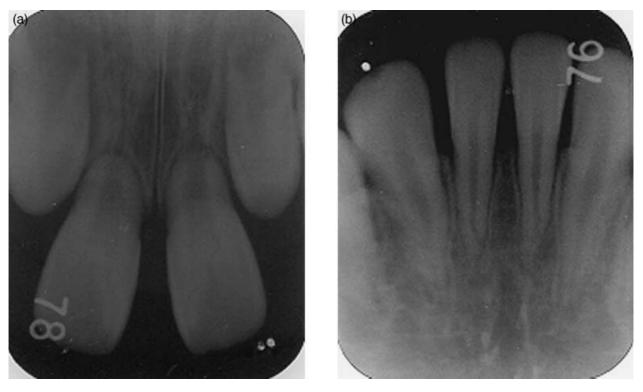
Dental radiographs of upper (a) and lower (b) incisors at the age of 8 years and 2 months.
